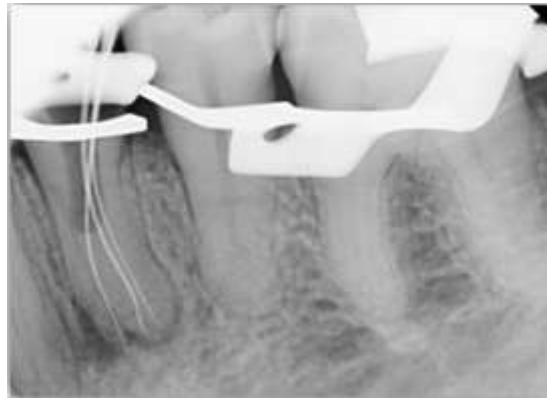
Working length determination using apex locator and radiographic confirmation
